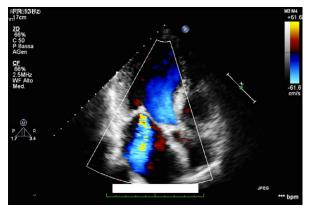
Preoperative echocardiogram (3-chamber view) shows heavy calcification of the aortic valve and moderate-to-severe mitral regurgitation caused by the tethering of both leaflets.
